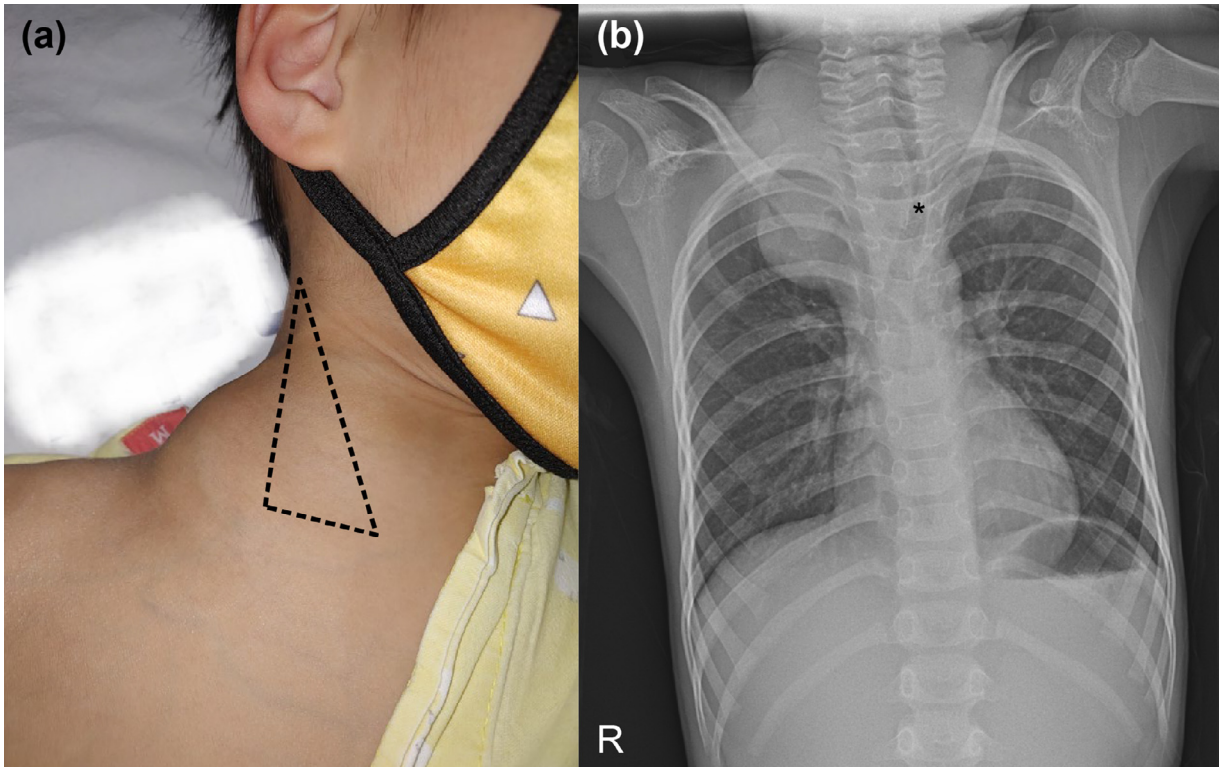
Location of the mass. (A) The 5-cm-sized mass is seen on the lower posterior triangle of the boy's right neck (dashed line). This location is consistent with the neck levels III–Vb. (B) The initial chest radiograph shows a right superior mediastinal mass with the trachea deviated to the left side (asterisk). Published under written consent of the boy's legal guardian.
